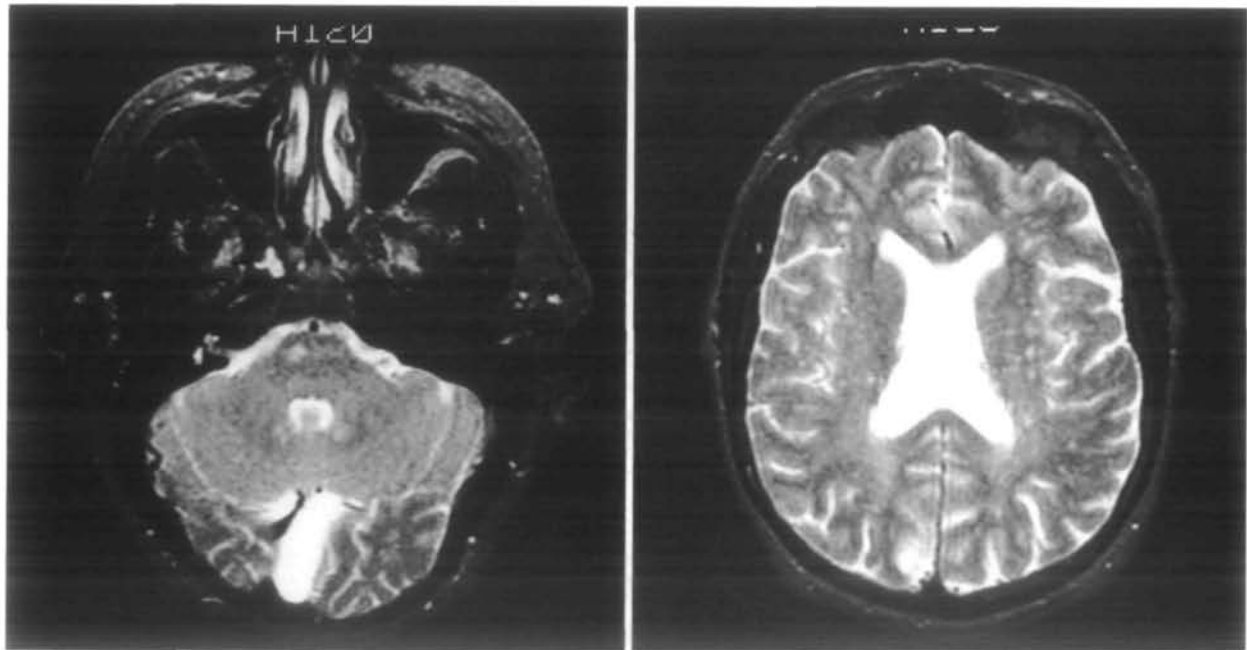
Magnetic resonance image scanning of the head revealed a discrete focus of increased T2 signal within the ventral right pons consistent with lacunar infarction. Multiple tiny areas of increased T2 signal were noted within the deep white matter bilaterally.
